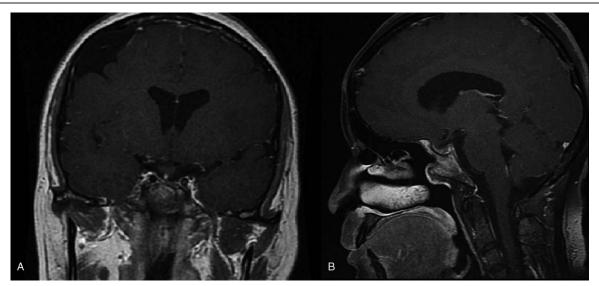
Postoperative magnetic resonance imaging (MRI) at the 7 months' follow-up on September 2017 following transsphenoidal debridement surgery. Postoperative coronal (A) and sagittal (B) views of the dense-enhancement image showed resolution of the abscess and no recurrence or residual pituitary abscess.
